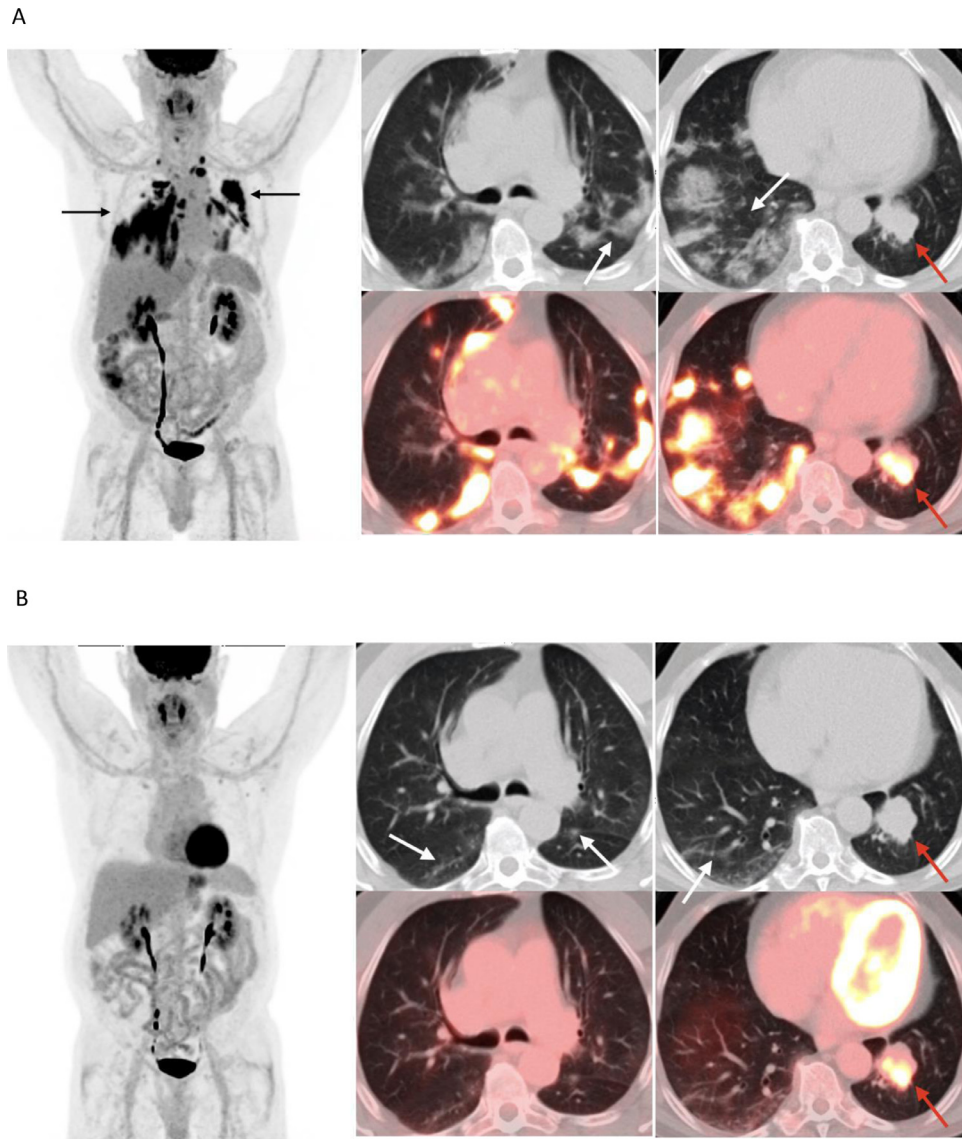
70-year-old male with lung adenocarcinoma on alectinib presenting for routine PET/CT. (Panel A) MIP image shows hypermetabolic lesions in bilateral lungs (black arrows). Axial CT and fused PET images show multifocal bilateral hypermetabolic ground-glass opacities and consolidation (white arrows) consistent with Covid-19 pneumonia, as confirmed by RT-PCR. Hypermetabolic left lower lobe mass (red arrow) consistent with primary malignancy. (Panel B) PET/CT obtained two months after shows near-complete resolution of bilateral opacities with minimal residual GGO. Subpleural parenchymal bands can be seen in the right lower lobe and left fissure thickening (white arrows). Persistent hypermetabolic left lower lobe mass (red arrow).
